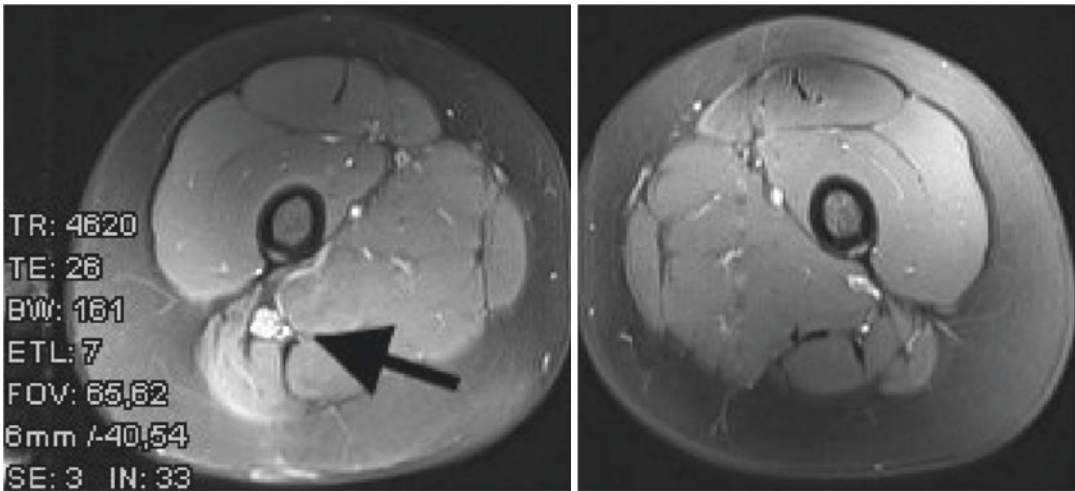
Example of an intraneural perineurioma of the right sciatic nerve (arrow) in MRI (sagittal) after application of gadolinium
